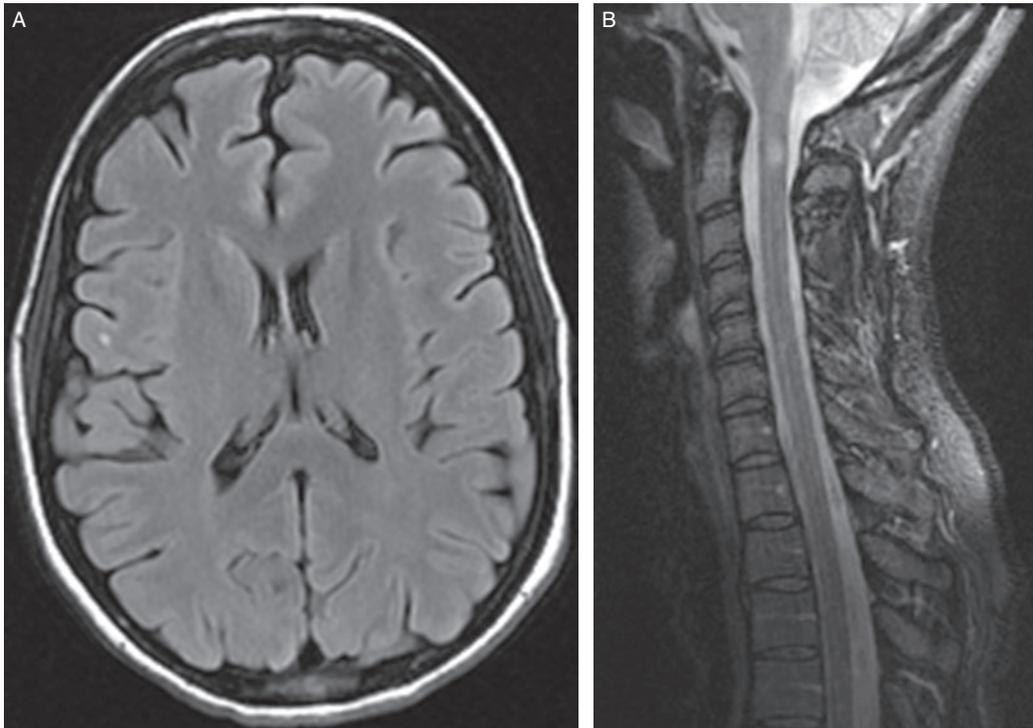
A) Axial FLAIR MRI brain showing small, non-specific lesion in right hemispheric white matter. B) Sagittal T2 MRI cervical spine short-segment, ovoid lesion characteristic of multiple sclerosis.
